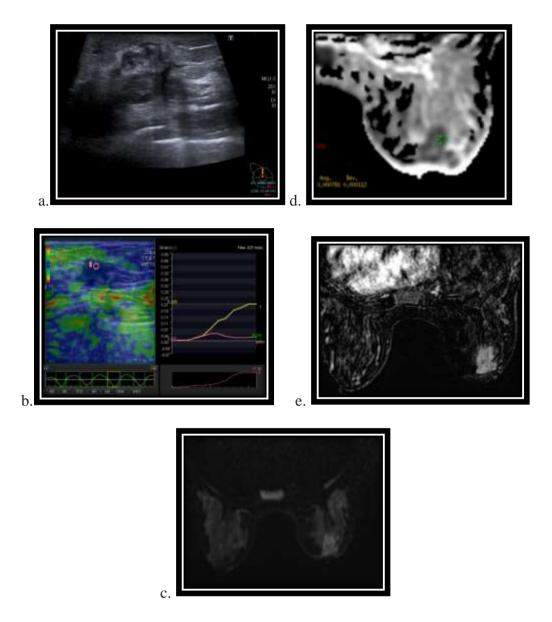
Retroareolar area of the right breast with gray scale USG (a) with irregularly defined lobulated contour, (b) SR value of 11.55 on US elastography, diffusion restriction on DWI (c), peripheral hypointensity on ADC map (d) and dynamic Contrast-enhanced examination (e) reveals a mass lesion with heterogeneous contrast-enhancing malignant character.
